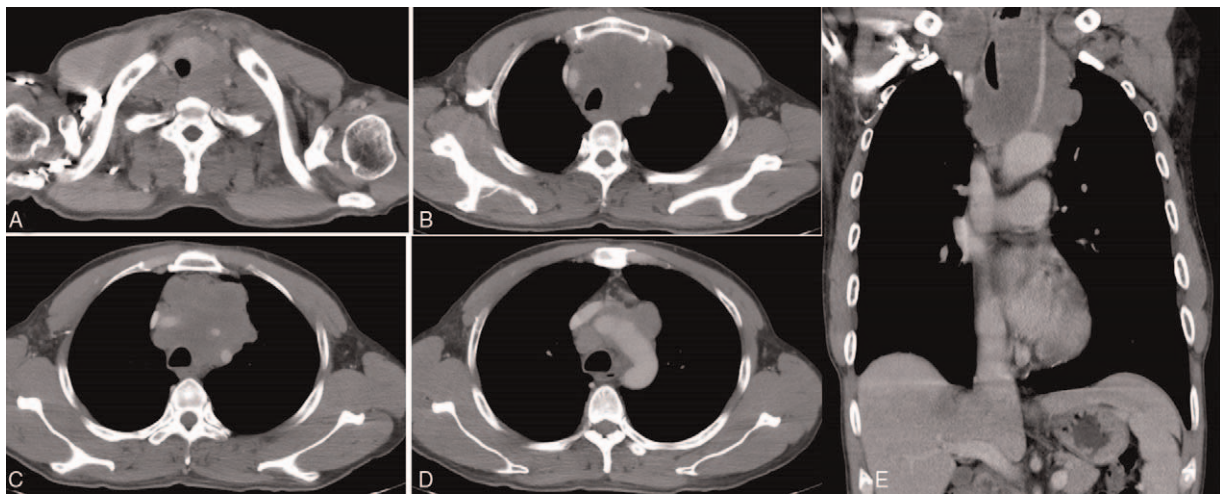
Contrast enhanced CT images showed the lesion was related to thyroid (A) (arrow head), heterogeneous enhancement (B and C) (arrow head), and enlarged lymph nodes (D) (arrow head). The left common carotid artery passed through the mass (E) (arrow head).
